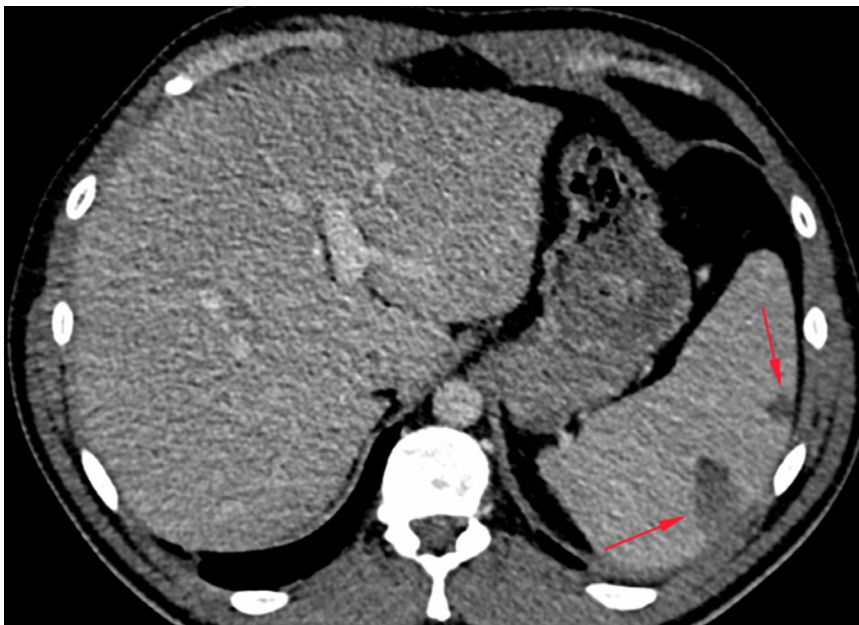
Splenic infarct areas on the abdominal CT.
